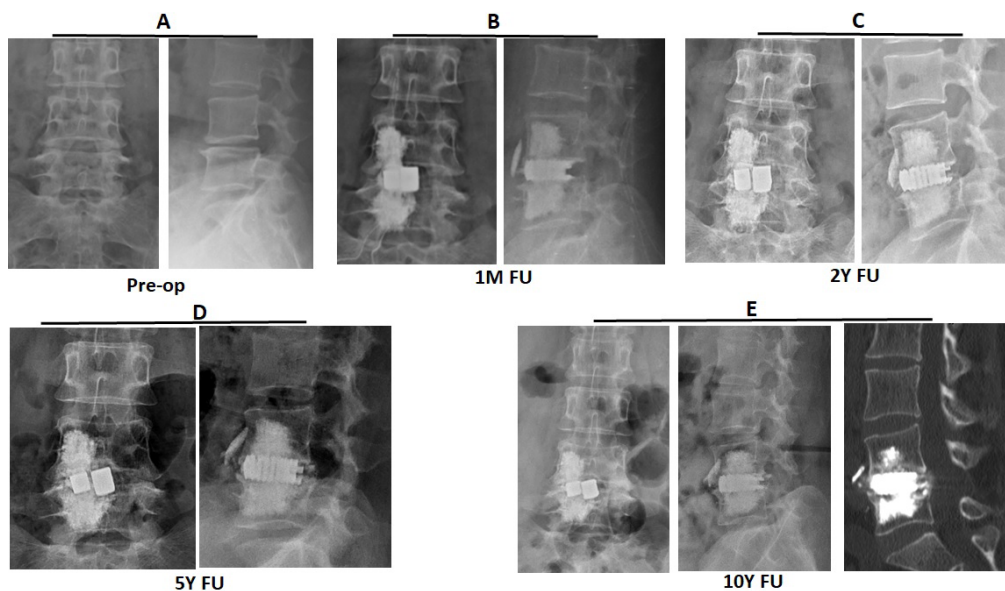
A 60-year-old female with L4/5 listhesis and spinal stenosis (A) received CLIF with asymptomatic cement leakage via L4 anterior cortex defect. The radiographs reveal the initial post-operative (B), 2-year (C), 8-year (D) and 10-year (E) follow-up.
